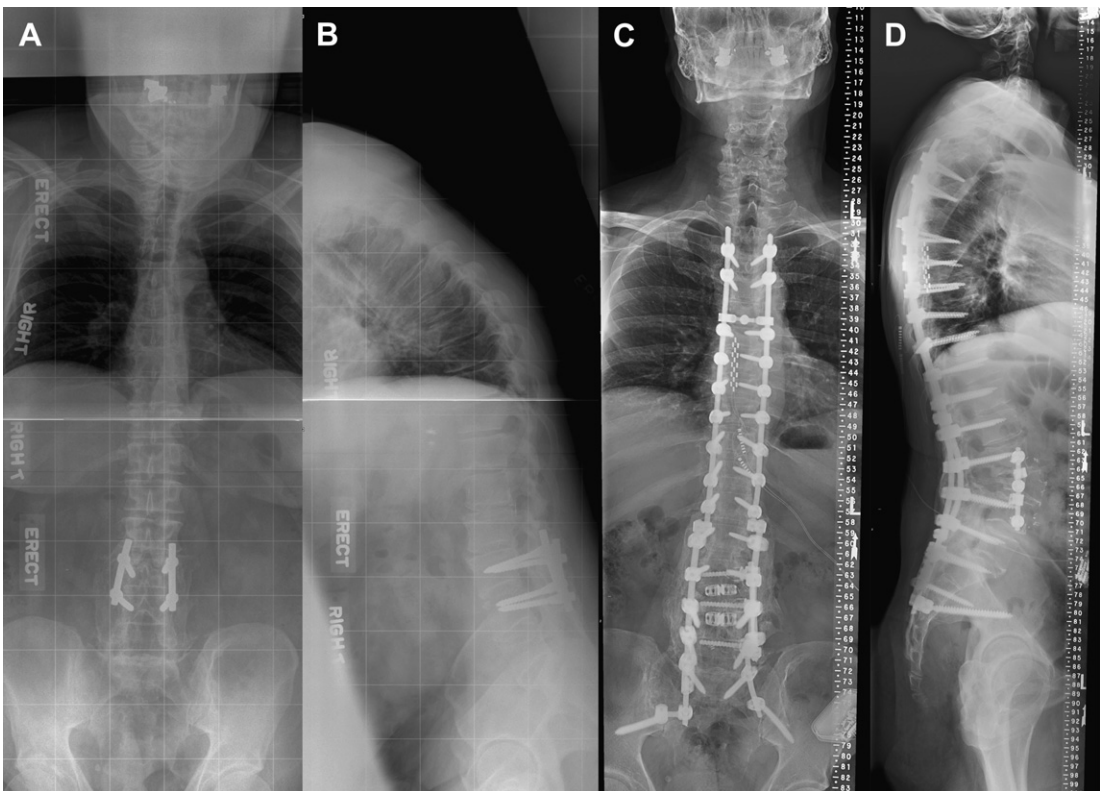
A 50-year-old man presented with radicular right leg pain, low back pain, and inability to maintain erect posture. (A, B) 91.44-cm (36-in) radiographs show severe sagittal imbalance (SVA 21.2 cm) and thoracic hyperkyphosis. (C, D) Postoperative 91.44-cm (36-in) radiographs after L3 pedicle subtraction osteotomy, T6 to 8 Smith-Petersen Osteotomy (SPOs), T3-pelvis posterior fusion and staged L2 to 3, 3 to 4 anterior lumbar interbody fusions (MiSLAT V treatment).
